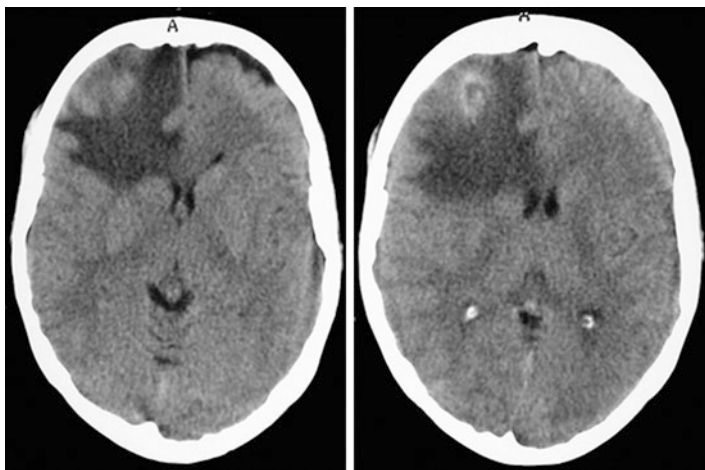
Non-contrast brain CT scan showing severe right frontal edema with mass effect. The right frontal horn is effaced (not seen) whereas the left is clearly seen. The sulci and CSF subarachnoid spaces are more easily seen on the left than on the right and there is midline shift to the left seen more clearly in the image on the right
